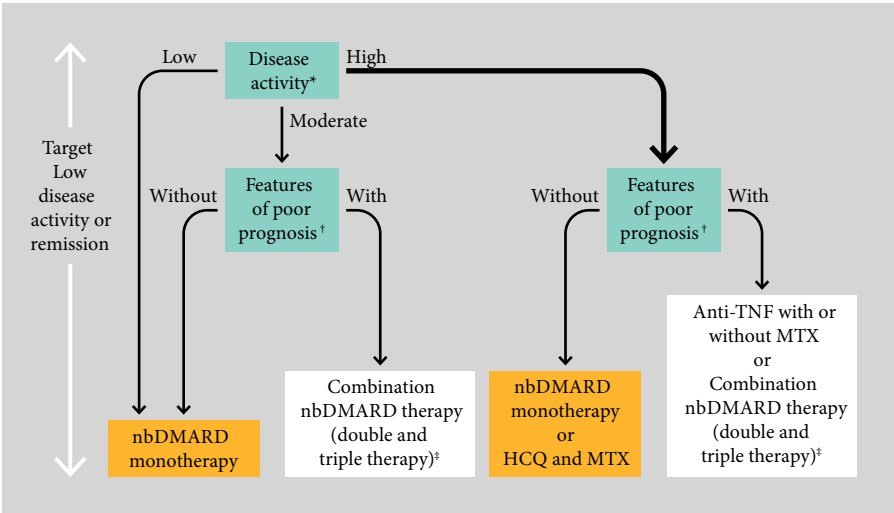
American College of Rheumatology (ACR) recommendations for the use of immunotherapies in early rheumatoid arthritis. *Disease activity assessed using a validated measure such as disease activity score (DAS); †Poor prognostic features include physical limitation (eg, Health Assessment Questionnaire score), extraarticular disease (eg, presence of rheumatoid nodules, rheumatoid arthritis [RA] vasculitis, Felty's syndrome), as well as rheumatoid factor/anti-citrullinated protein antibodies (ACPA) positive and radiographic erosions; ‡Combination nonbiologic disease-modifying antirheumatic drugs (nbDMARDs) therapy with two nbDMARDs (commonly including methotrexate [MTX]) and triple therapy (MTX, sulfasalazine, and hydroxychloroquine). Reproduced with permission from Singh et al [5] ©Wiley.
